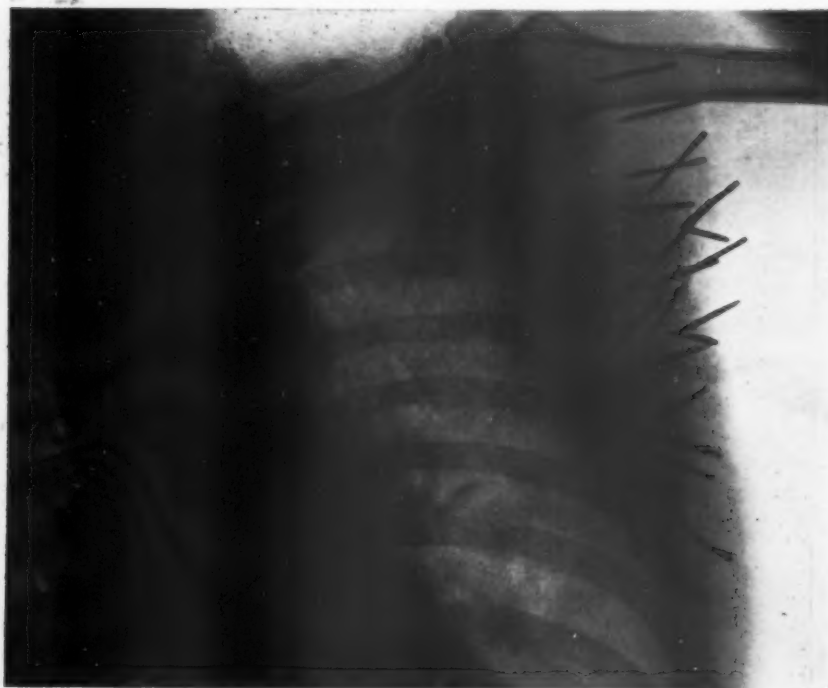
Roentgenogram of Figure III., showing the needles in position.
